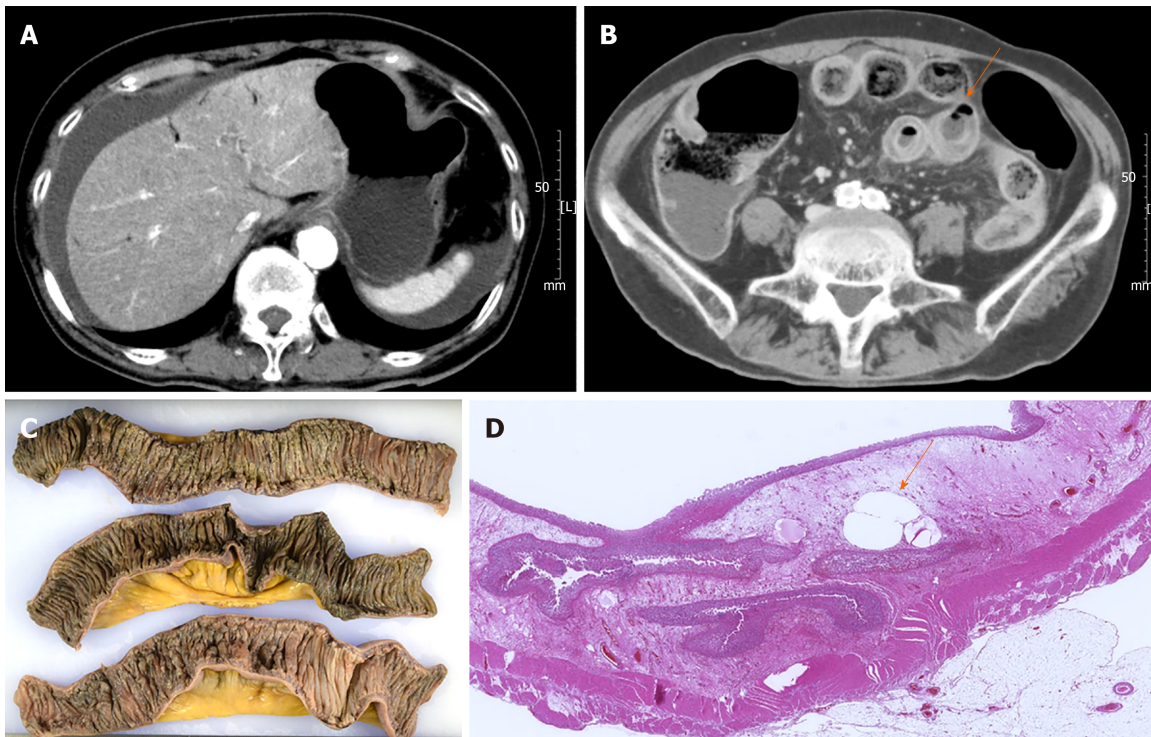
Computed tomography and pathologic findings of case 1. A: Abdominal computed tomography images on admission demonstrate hepatic portal venous gas, ascites; B: Intestinal pneumatosis (arrow); C: The resected small intestine shows hemorrhagic necrosis; D: Air-bubbles in the damaged intestinal wall (arrow).
